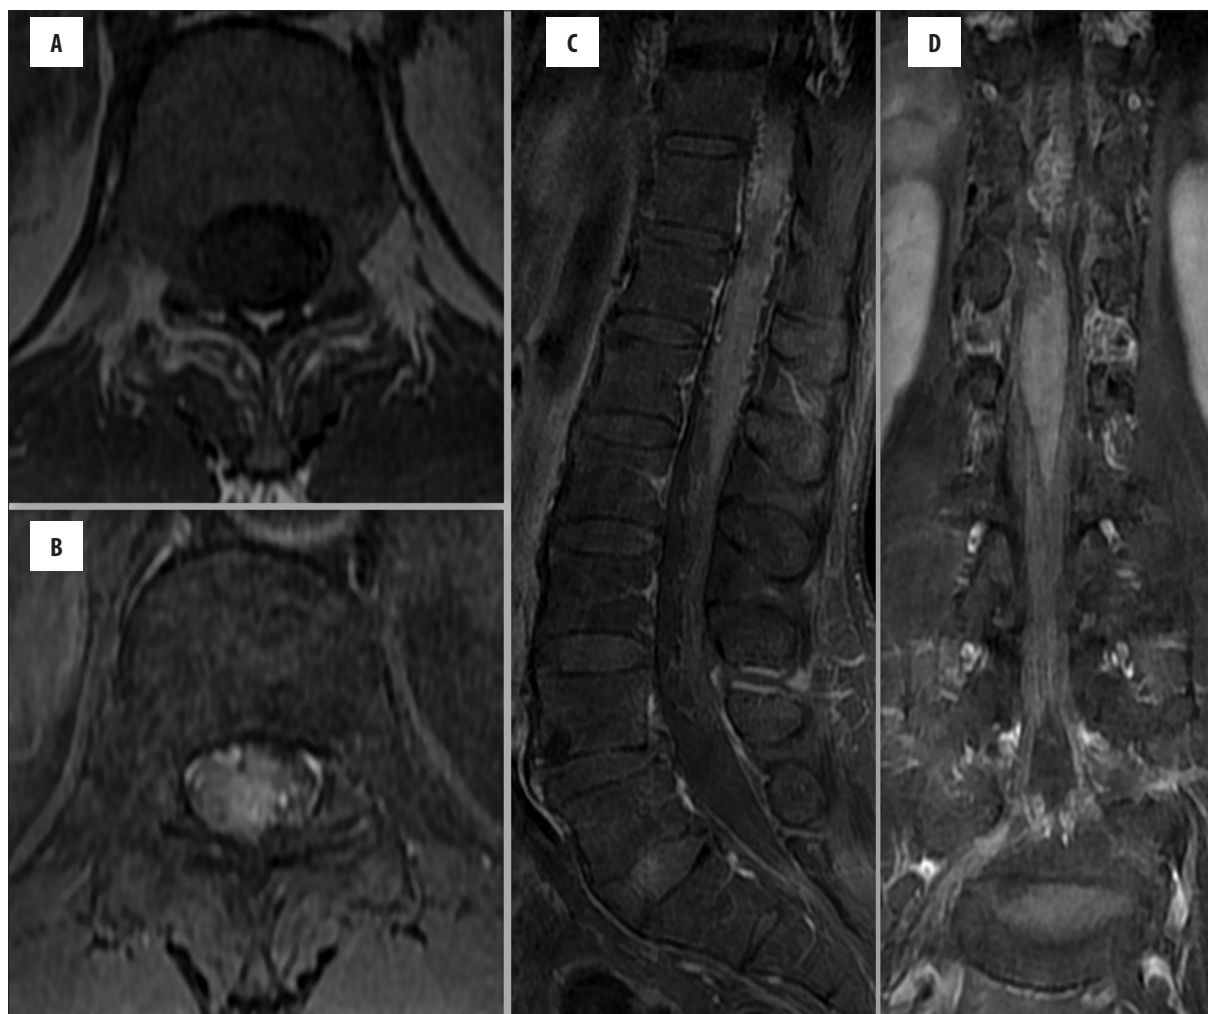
Axial T1-weighted (TR=640 ms, TE=9.4 ms) noncontrast image at lower dorsal level (A) and following intravenous gadolinium administration, fat saturated, T1-weighted (TR=640 ms, TE=9.4 ms) axial (B), sagittal (C) and coronal (D) images demonstrate significant post-contrast enhancement of the lower cord and conus medullaris.
